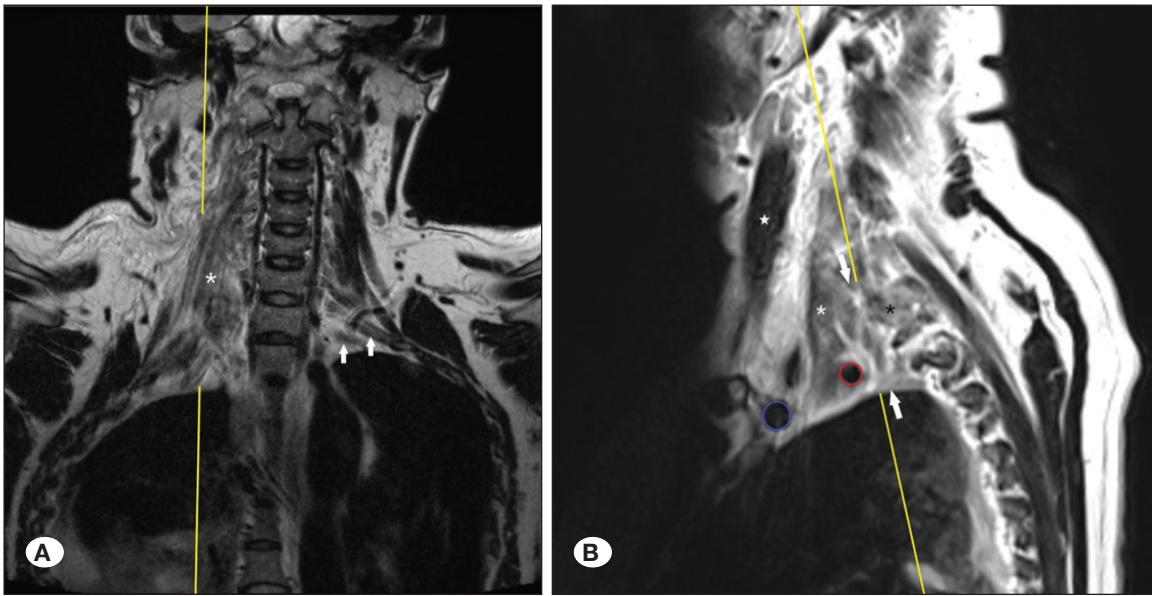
MRI of the brachial plexus. A) T2W coronal sequence showing edema of the right scalene muscles (SM) (white asterisk) that obscures the trunks of the right plexus, which can be seen contralaterally (white arrows). B) T2W sagittal sequence showing the trunks of the right plexus (white arrows) and the anterior and middle SM (white and black asterisks). The edema of the SM can be compared with the normal sternocleidomastoid muscle (white star).
